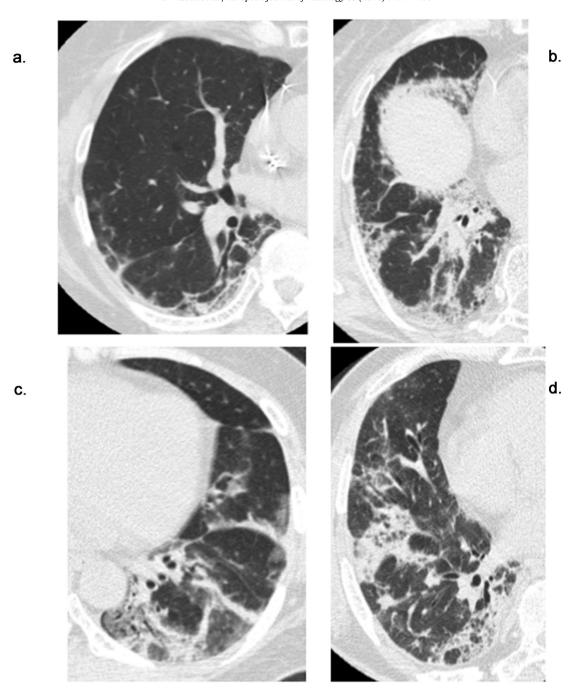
Ragiologic diagnosis. OP with fibrosis. (a) Thin-section CT scan of the right lung in a 67-year-old woman with ARS-ILD (EJ) shows NSIP pattern. (b) Thin-section CT scan of the right lung in a 72-year-old woman with ARS-ILD (EJ) presents NSIP pattern. (c) Thin-section CT scan of the left lung in a 56-year-old woman with ARS-ILD (Jo-1) demonstrates OP with fibrosis pattern. (d) Thin-section CT scan of the right lung in a 66-year-old man with ARS-ILD (PL-12) depicts OP with fibrosis pattern.
